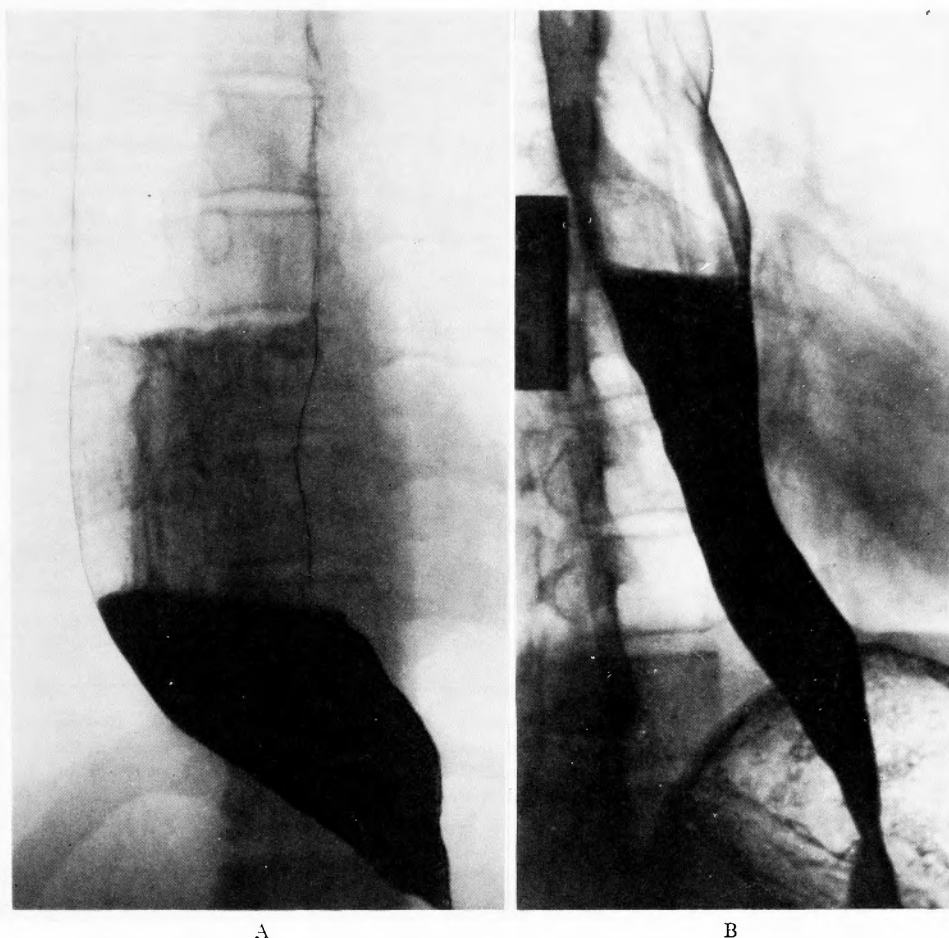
Roentgenogram of the esophagus before (A) and three weeks after (B) long esophagomyectomy for achalasia.
